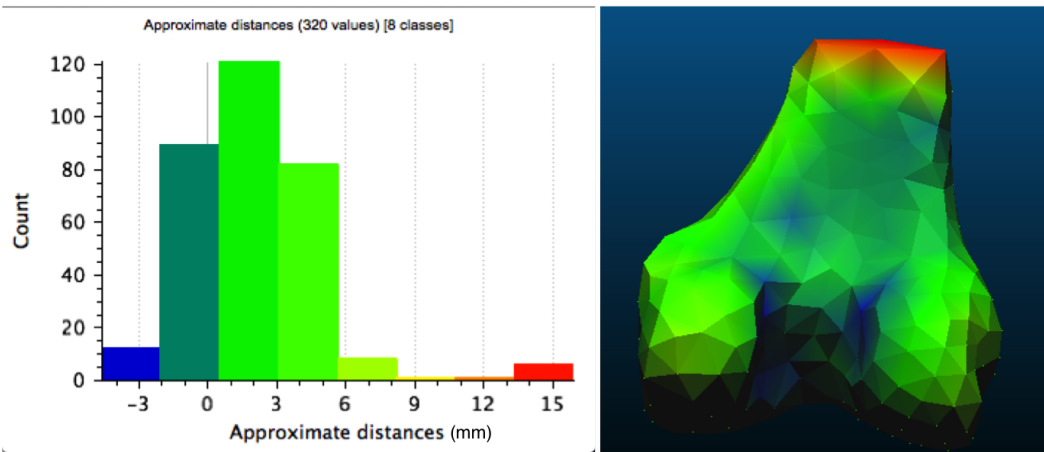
Similarity between the original CT mesh and the reconstructed SSM mesh
